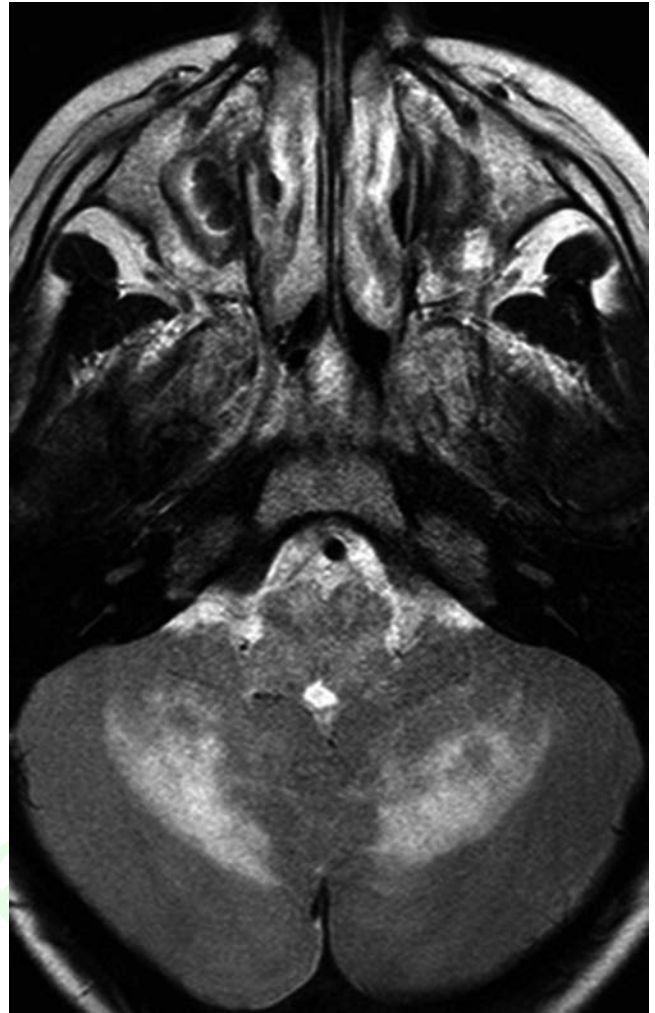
Axial magnetic resonance imaging scan showing diffuse bilateral signal abnormality in the cerebellum in a patient with neurodegenerative Langerhans cell histiocytosis.
